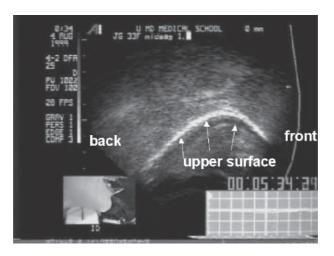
An ultrasound image of the sagittal (lengthwise) tongue. The white line is the upper surface of the tongue.
